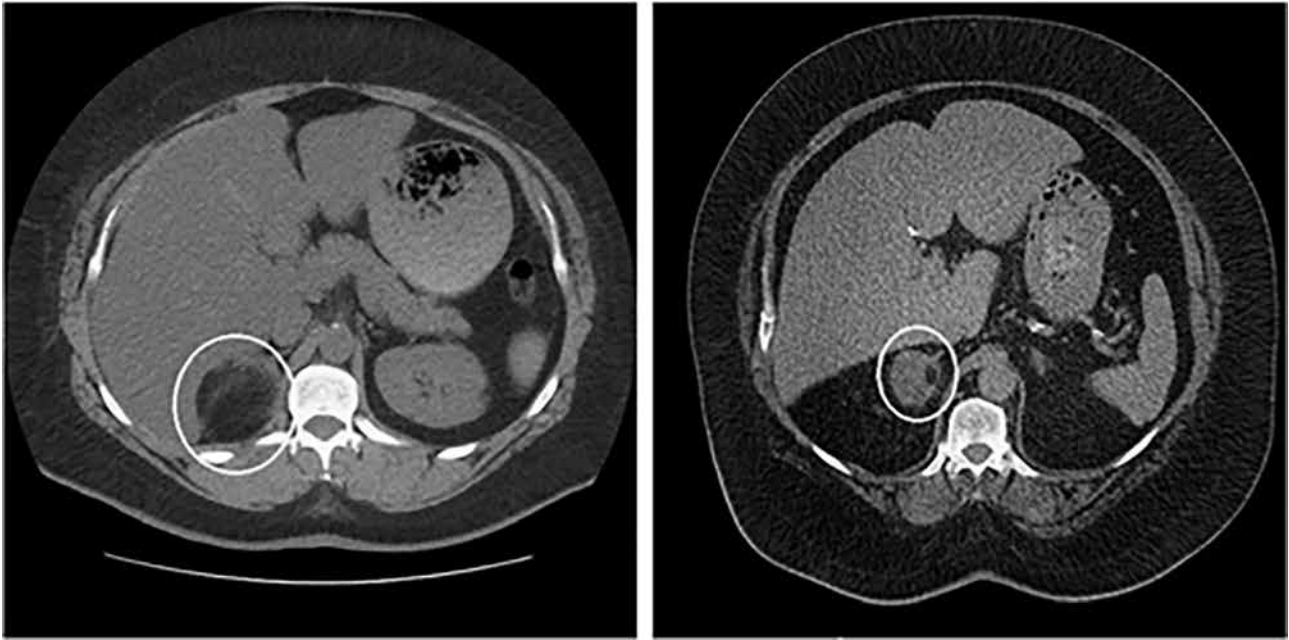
Myelolipoma of almost 100% macroscopic fat (circle) is observed in the right adrenal gland on axial unenhanced CT (A). Its attenuation value is lower than of myelolipoma containing approximately 10% macroscopic fat (B). (Campbell MJ, Obasi M, Wu B, Corwin MT, Fananapazir G. The radiographically diagnosed adrenal myelolipoma: what do we really know? *Endocrine* 2017; 58: 289-294)
